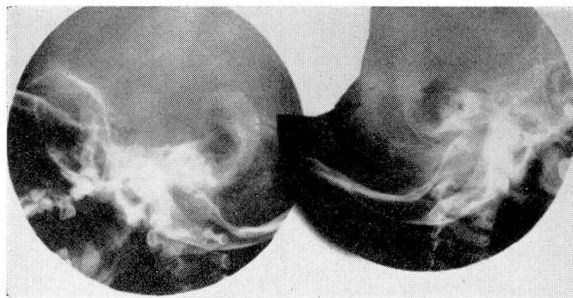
Roentgenograms reveal large destructive areas in both mastoid regions resembling operative defects.
